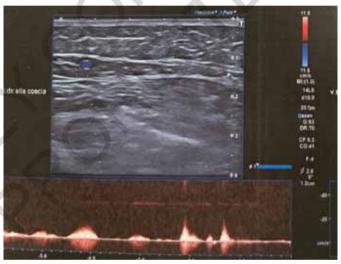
Ultrasound image. No pathological refluxes on the right internal saphenous axis which is regularly patent.
